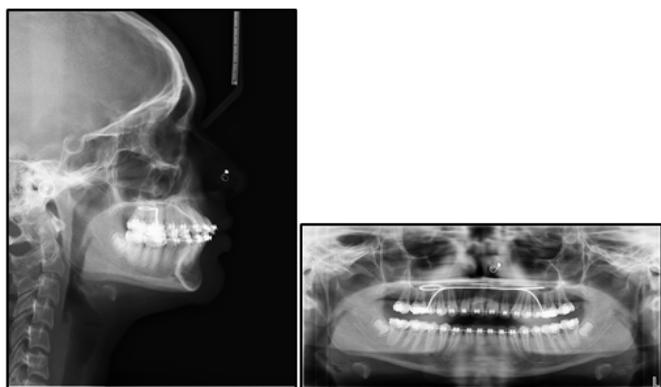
MID TREATMENT RADIOGRAPHS
